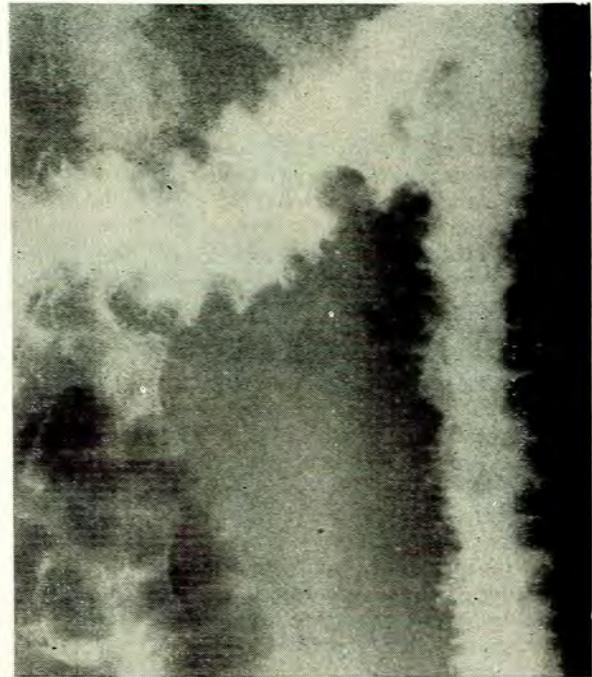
X-ray film of splenic flexure of a patient outlined during barium enema showing large 'thumb-print' filling defects resulting from ischaemic colitis.
